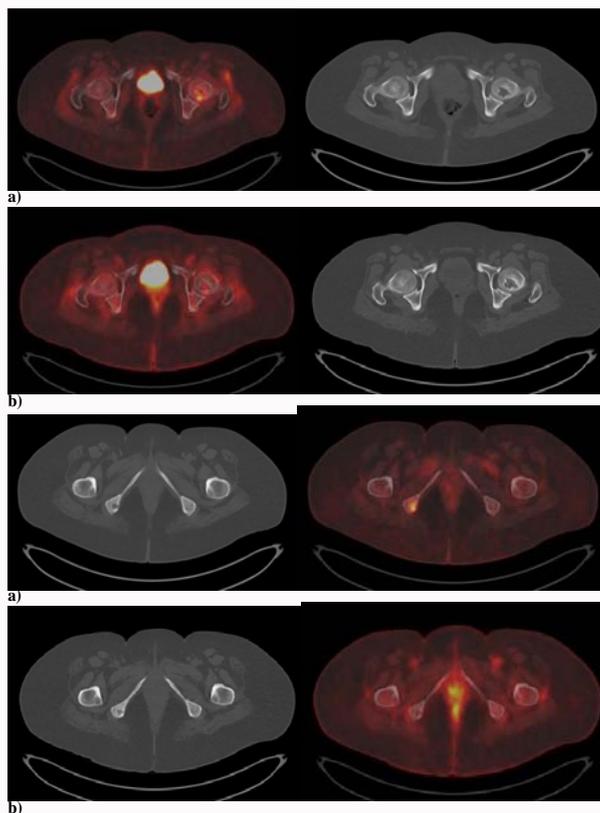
49 Year female with bone metastases. PET/CT images obtained at baseline (a) and follow up after treatment (b): Shows multiple FDG avid osteolytic bone metastases on baseline. Follow up shows Stable disease by RECIST 1.1 and complete metabolic response by PERCIST 1.0.
